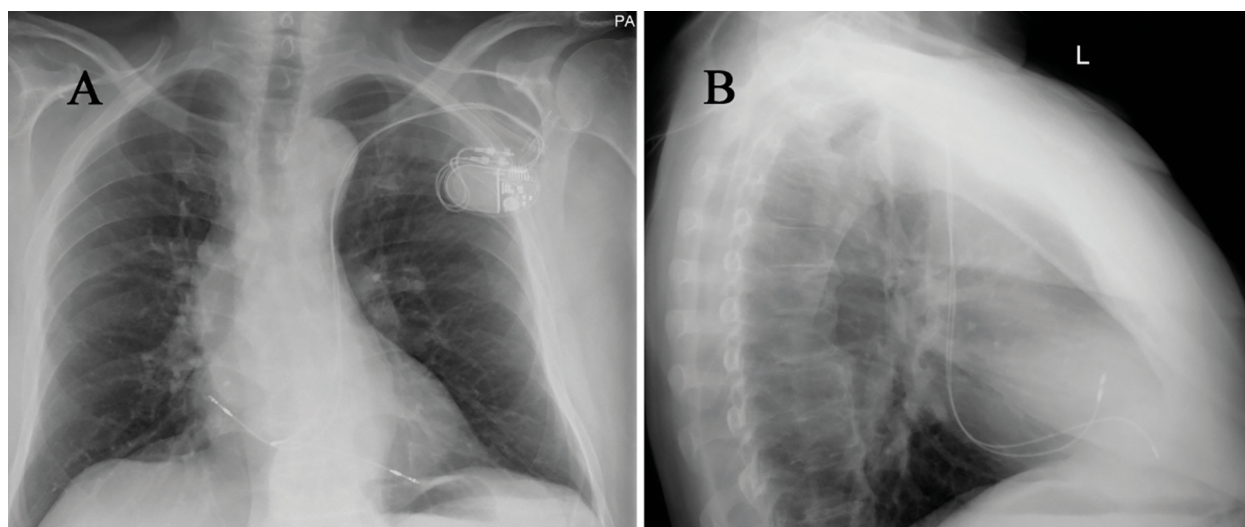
A post-procedure chest X-ray showing the course of both leads and the position of their tips in the chambers of the right heart: A. PA view; B. Lateral view
